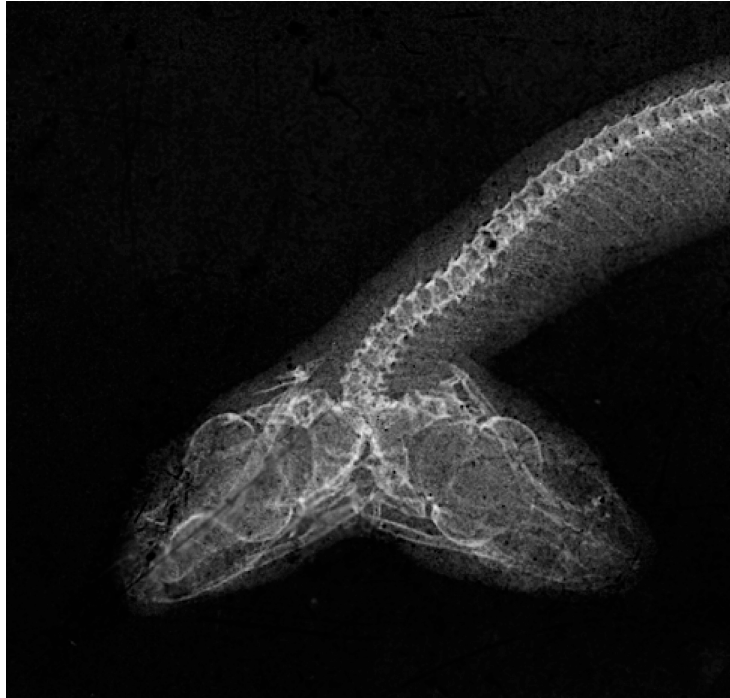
Radiograph (X-ray) of two-headed *Crotaphopeltis hotamboeia* from KwaZulu-Natal.
